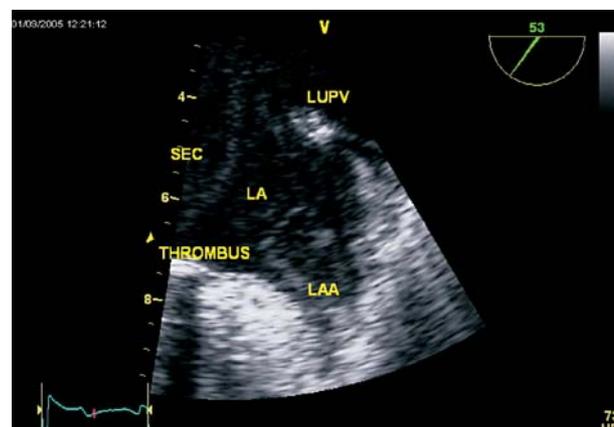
Transoesophageal study: focus on the left atrial appendage (LAA), within which a thrombus can be seen. LA – left atrium; LUPV – left upper pulmonary vein; SEC – spontaneous echo contrast.
